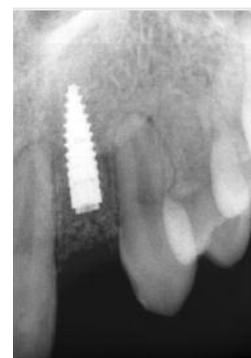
Immediate post-operative picture showing closure and radiograph.
